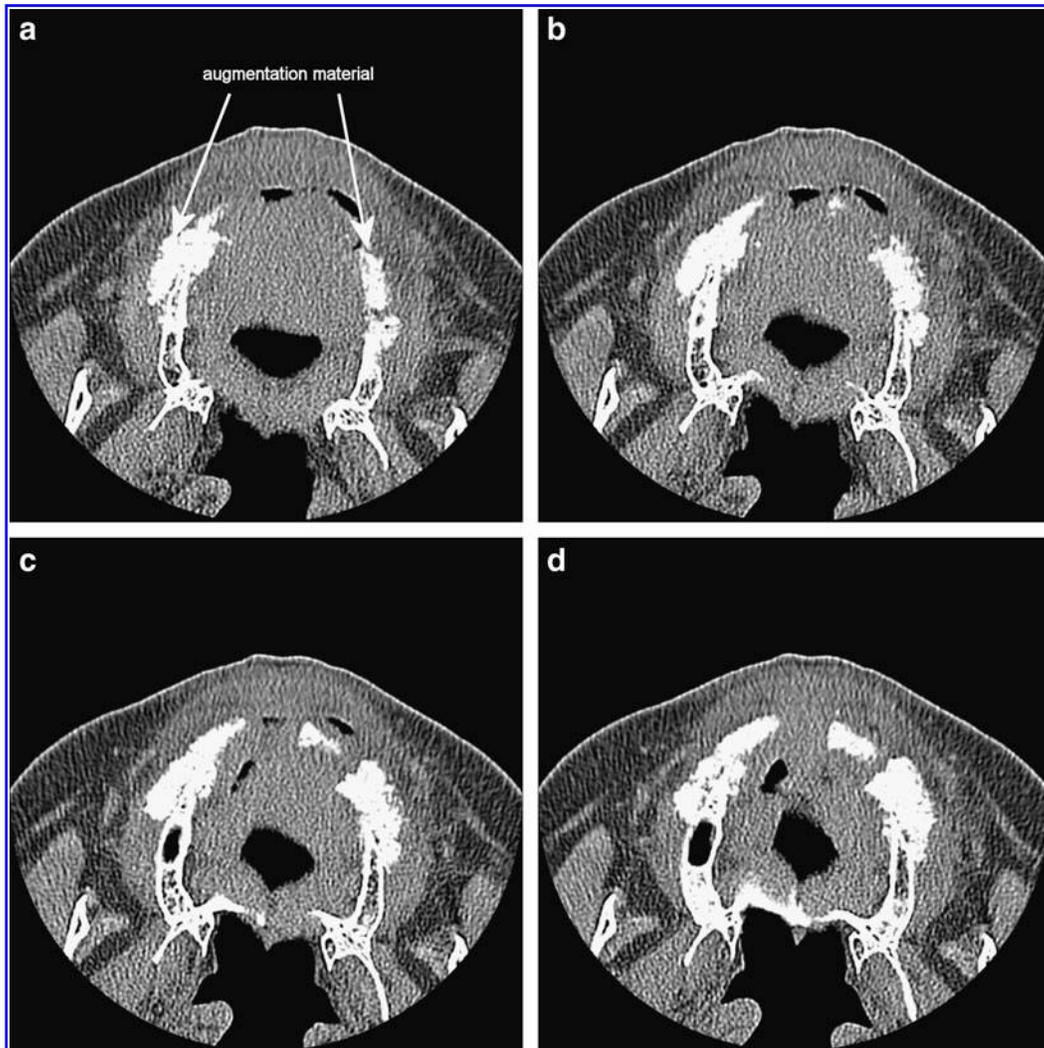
(a–d) CT 2 weeks postoperative with augmentation material (caudal to cranial levels).
